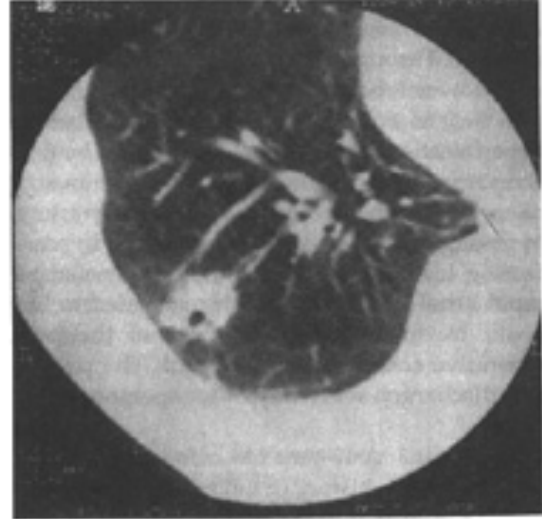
CT scan of the chest showing the well rounded opacity with central cavitation (Case 1).
